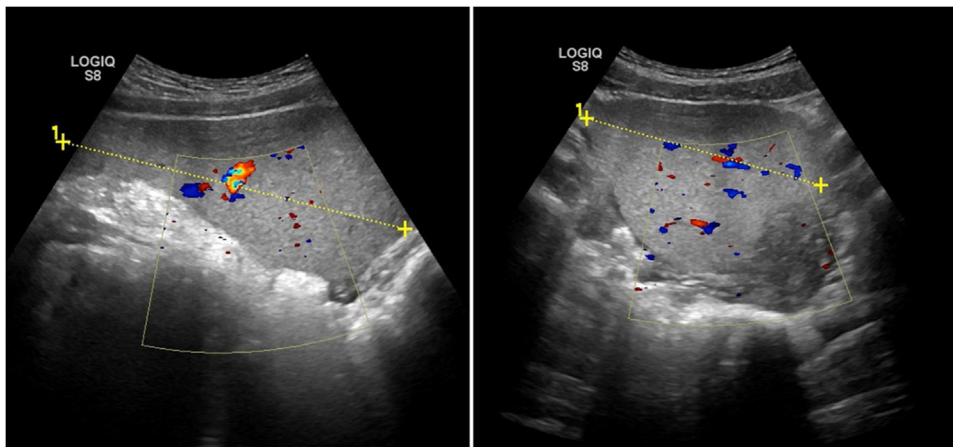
Ultrasound and Doppler showing a large vascularized pelvic mass.
